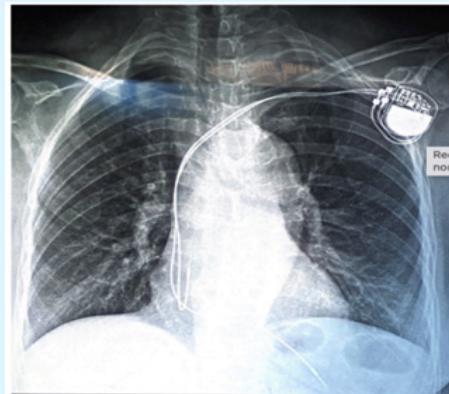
Chest radiograph Revels displacement of the ventricular pacing lead
